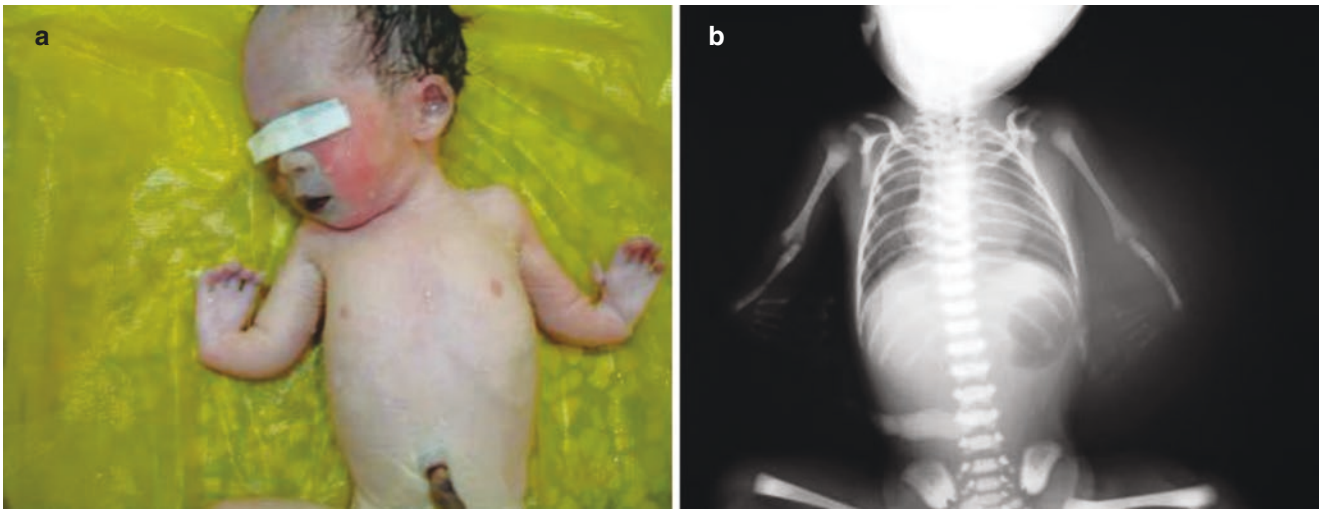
Absent radius in the forearm after induction labor. (a). Picture after labor induction (b). X-rays of the same induced fetus
